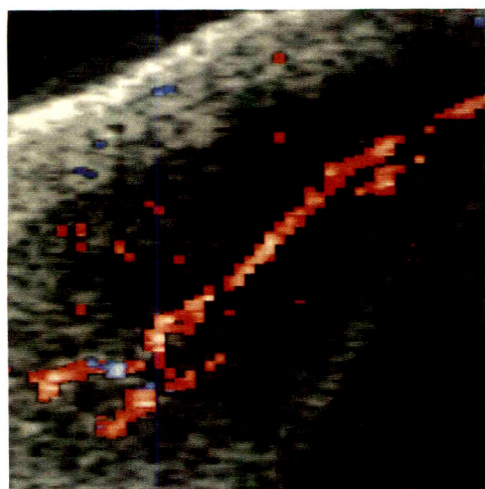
Right cavernosal penile artery imaged sonographically after intracorporal injection of papaverine. Differential systolic streamline flow is appreciated in segments of this 2-mm-diameter vessel. Color flow signal is also seen in some helicine vessels traversing image plane.
